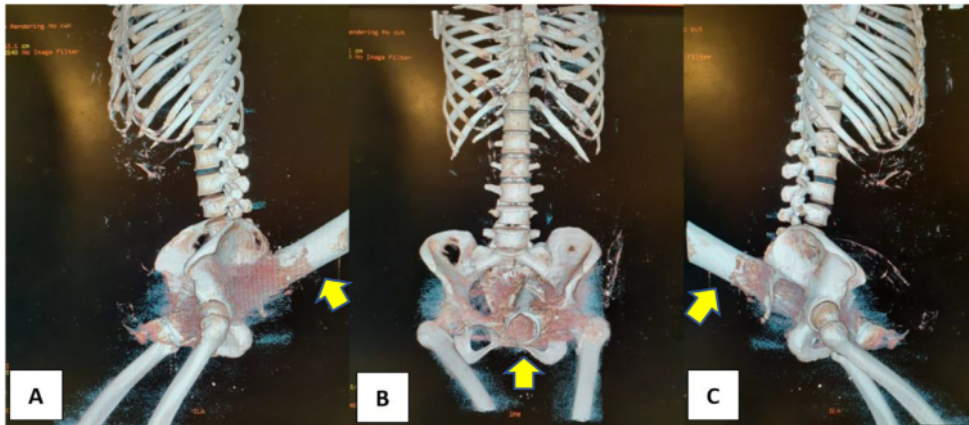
Abdominal 3D CT-scan of the lower abdomen and pelvic shows an iron object (arrow) penetrated the inguinal region and the right pelvic.
